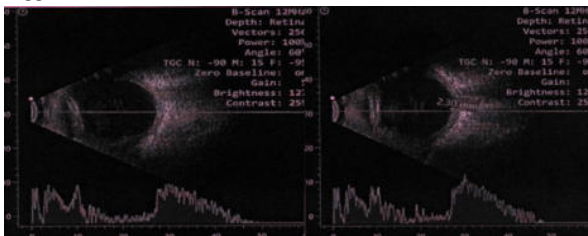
B-scan ultrasonography demonstrating dense vitreous echoes consistent with vitritis and an attached retina.
